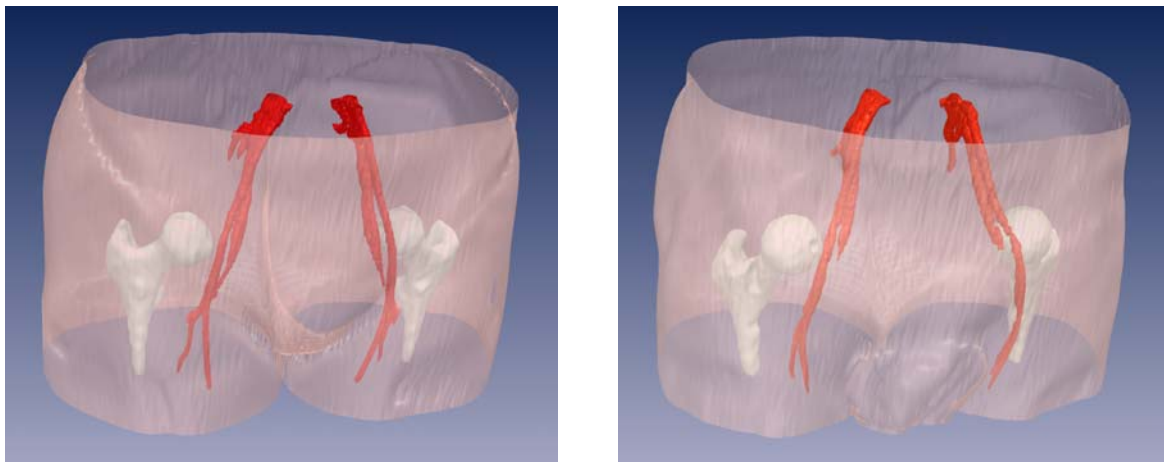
Iso-surfaces for skin, vessels and (incomplete) bone tissue extracted from two MRI scans using the proposed segmentation script without additional adjusting parameters: female (*left*); male (*right*)
